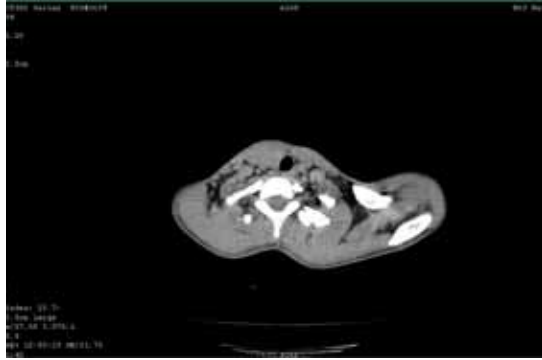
Plain CT study axial section showing absent left thyroid lobe.
